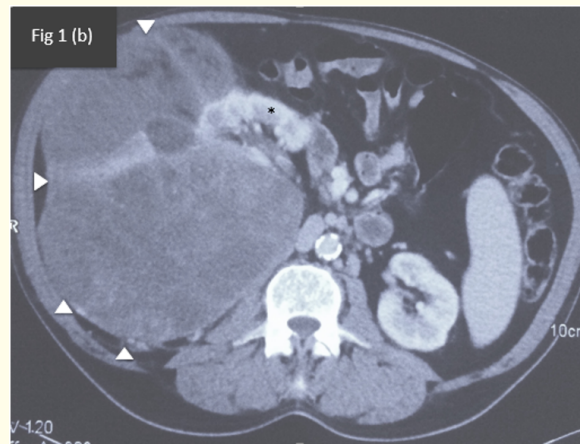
Contrast enhanced computed tomography scan showing heterogeneous mild post contrast enhancement of the well-defined perirenal mass (white arrowheads) surrounding and compressing the right kidney (*).
